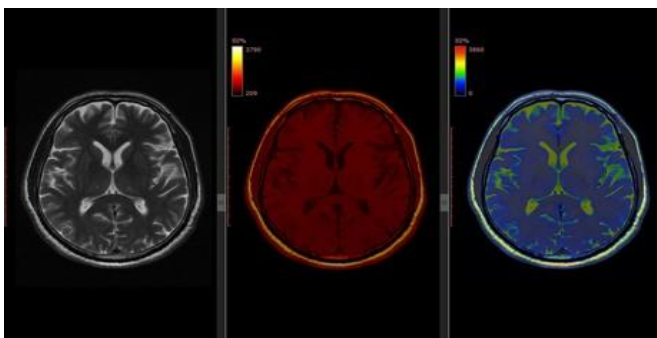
MRI images of PET Image optimizations
